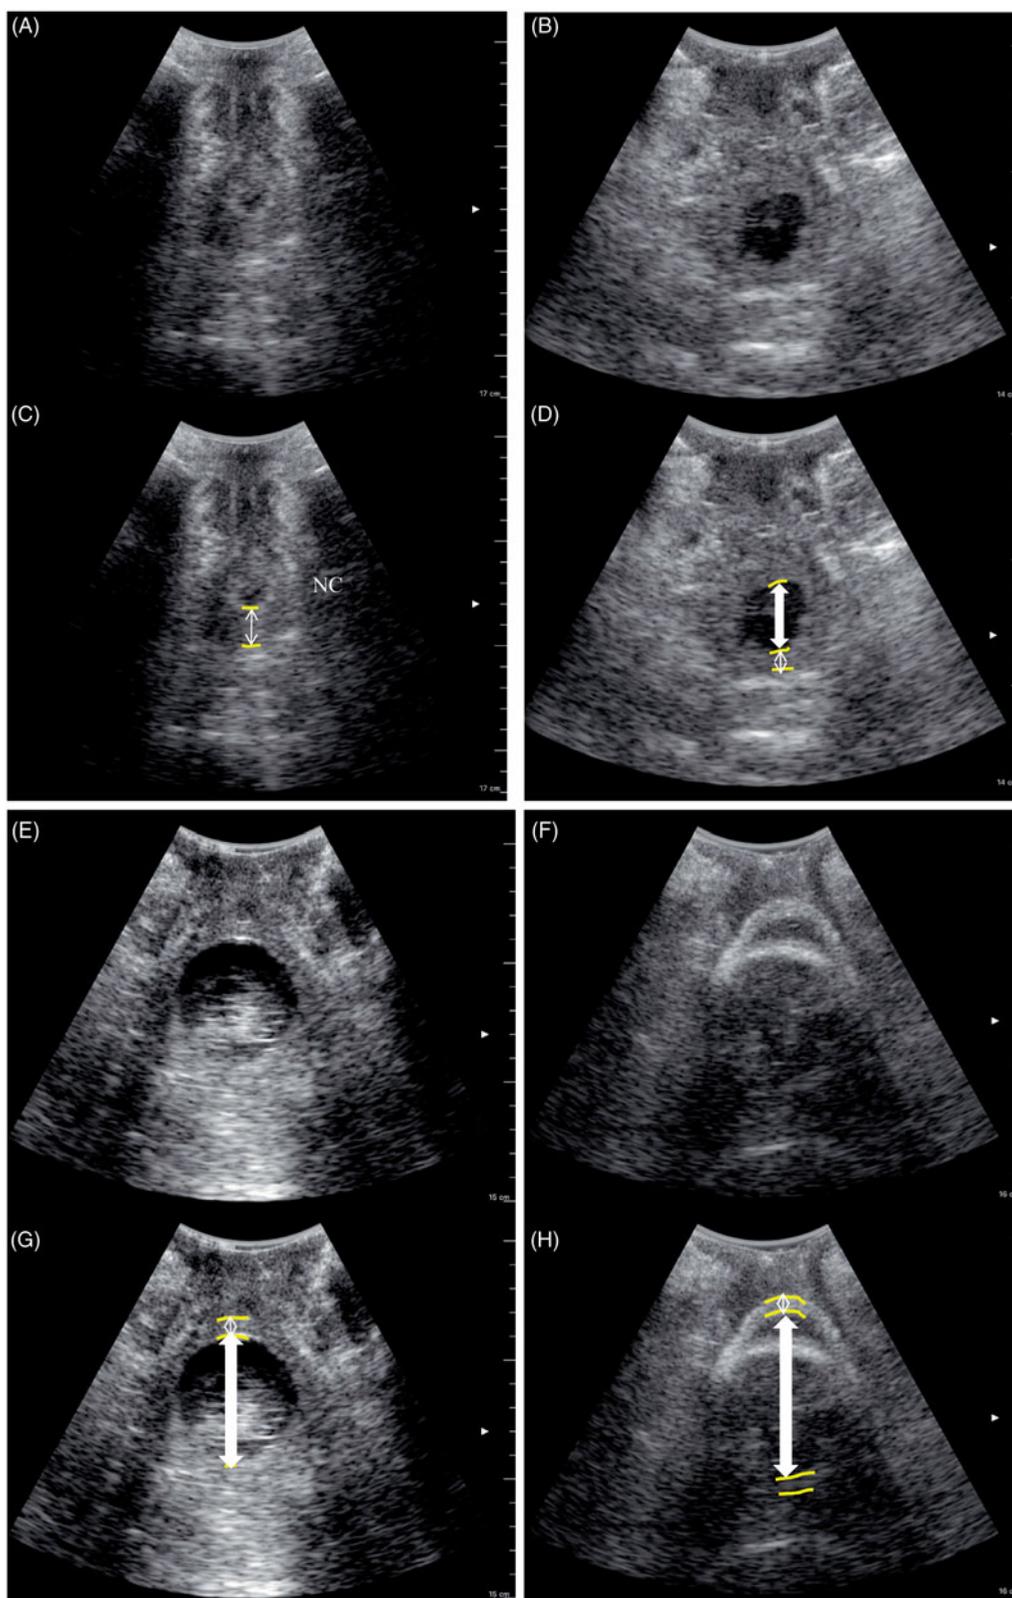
The transperineal transverse approach provides a cervical dilatation view. Inner to inner length represents cervical dilatation (thick arrow). In the same image, cervical thickness was measured via the inner and outer distance (thin arrow). All images were collected with the wireless mobile ultrasound SONON 300c linked to a fourth generation iPad (iOS version 8.3, application version m1.1.13). (A, C) When the dilated area was too small to measure, we categorized it as a non-circular space. Cervical thickness of 1.7 cm. Cervical dilatation and cervical thickness of (B, D) 2.7 cm and 0.8 cm, respectively; (E, G) 5.2 cm and 0.6 cm, respectively; and (F, H) 7.2 cm and 0.55 cm, respectively.
